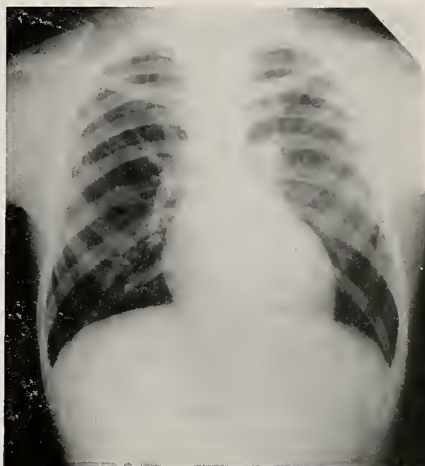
Case II—X-Ray: Interventricular Septal Defect (Roger's Disease)
